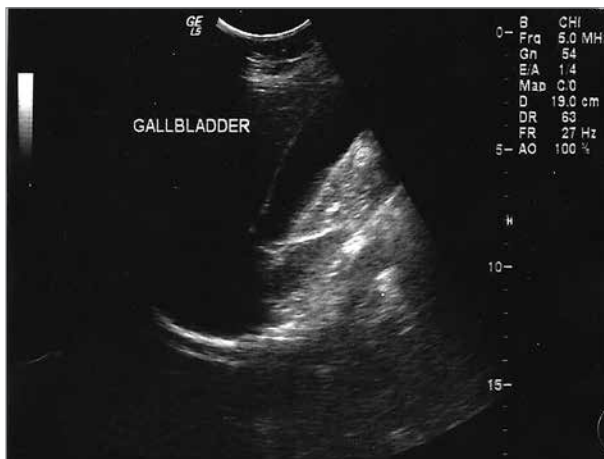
Abdominal ultrasound showing a well distended gallbladder with hyperechoic fluid-posterior acoustic shadow indicating milk of calcium gallbladder
